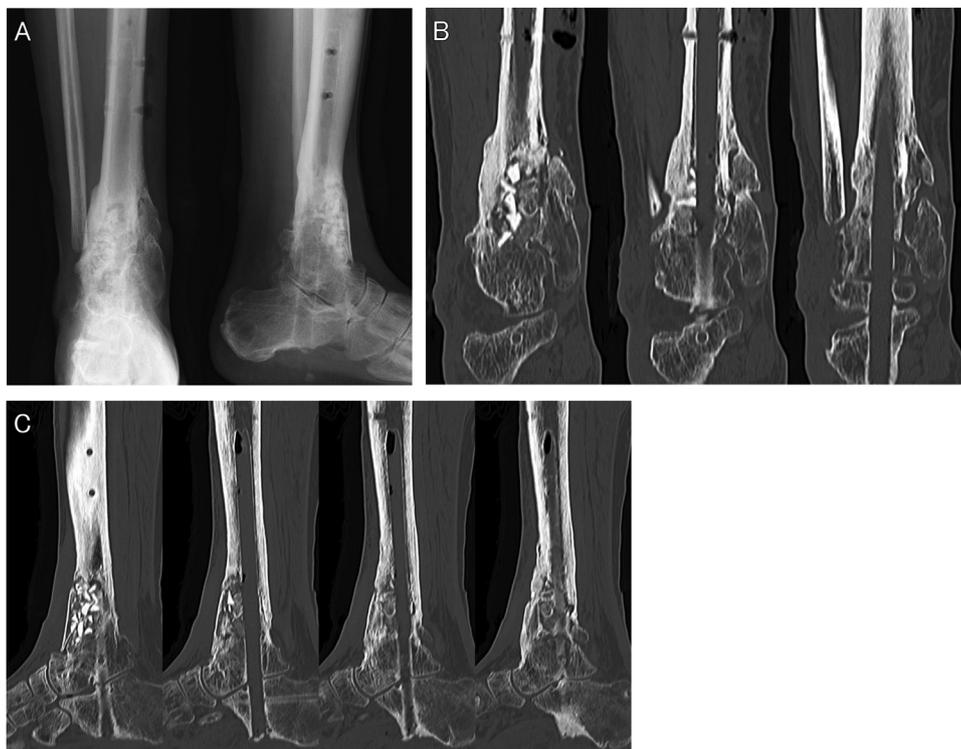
Firm bony union was achieved and the nail was removed at 1 year after the arthrodesis surgery. XR (A) and CT images (B, C) just after removal of the implant.
